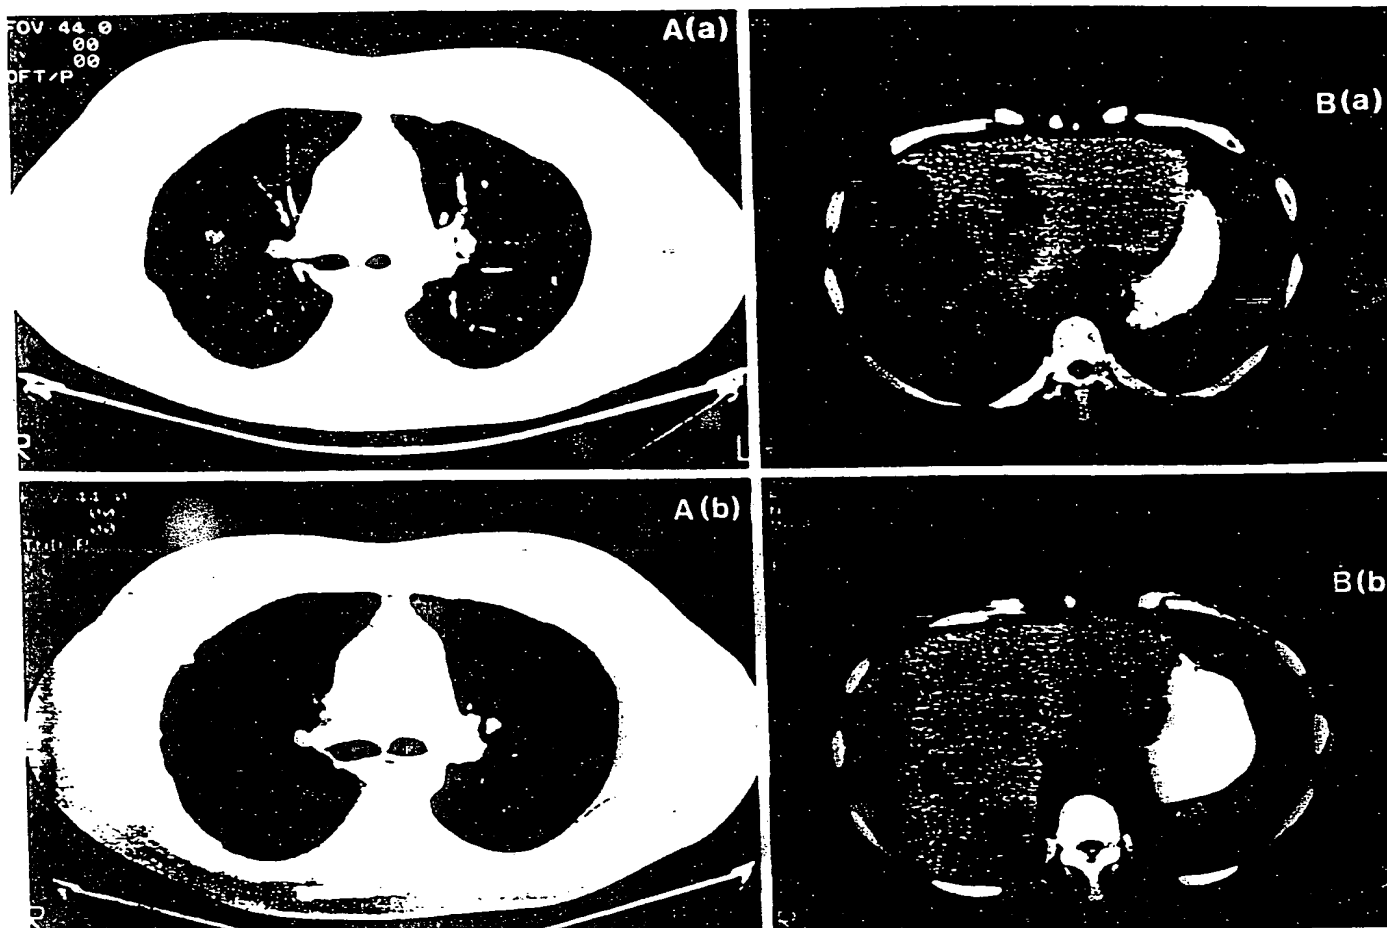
A. CT of the chest before (a) and during (b) treatment with gossypol (50 mg/day) in a 36-yr-old male with metastatic adrenal cancer. B. CT of the liver before (a) and during (b) gossypol treatment in the same patient.
